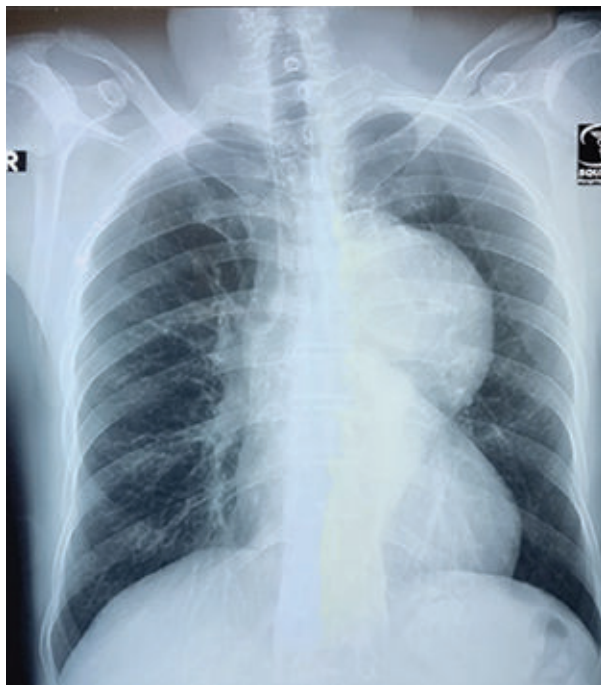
X-ray chest PA view showing large aortic aneurysm compressing the left hilum and left lung
